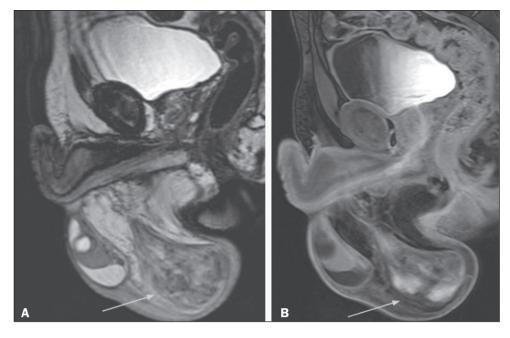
Liposarcoma of the scrotum. Sagittal T2-weighted image without fat suppression (A) and contrast-enhanced sagittal T1-weighted image with fat suppression (B), showing a large nodular lesion in the subcutaneous tissue of the right scrotum. with solid areas of high signal intensity on the T2-weighted image and early contrast enhancement (B), interspersed with areas of fat, related to liposarcoma of the scrotum, which was confirmed after surgery. Macroscopic fat can be identified as high signal intensity on T1- and T2-weighted images and low signal intensity on fatsuppressed sequences<sup>(2,4,5)</sup>. In addition, chemical shift artifacts can be observed at the interface between the soft tissues and the intratumoral fat components, as can heterogeneous contrast enhancement<sup>(2,4)</sup>.
